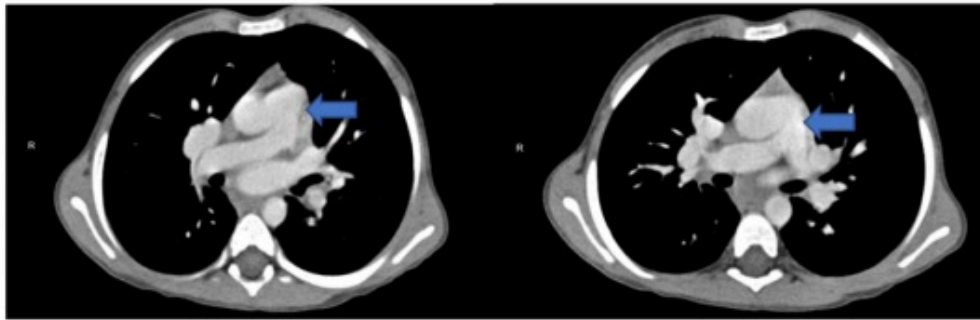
Aortopulmonary window CT angiography image from two different sections marked with a blue arrow.
